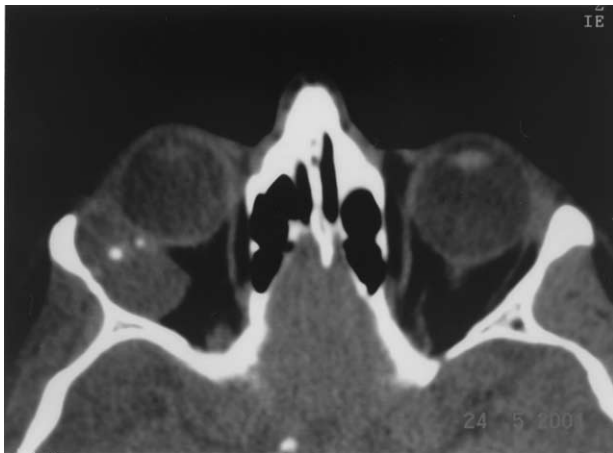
Axial computed tomographic scan of the orbits demonstrates a large homogeneous mass with several foci of calcification involving the lacrimal gland fossa.
